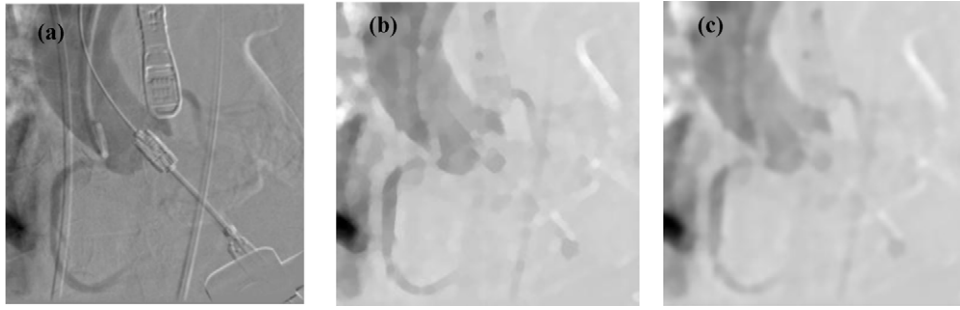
2-D X-ray image processing. (a) The digitally subtracted image (DSA) of an aortic angiography; (b) DSA image after morphological filtering; and (c) DSA image after Gaussian filtering.
